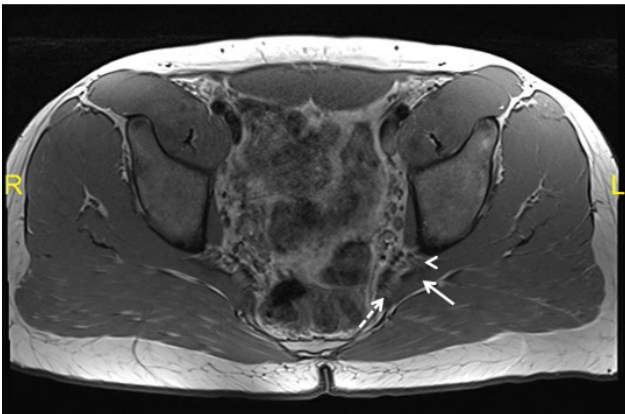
Axial T1-weighted MRI image of type 2 sciatic nerve. Solid white arrows: piriformis muscle; dashed white arrow: common peroneal component piercing the piriformis; white arrowhead: tibial component passing anterior/below the piriformis.
